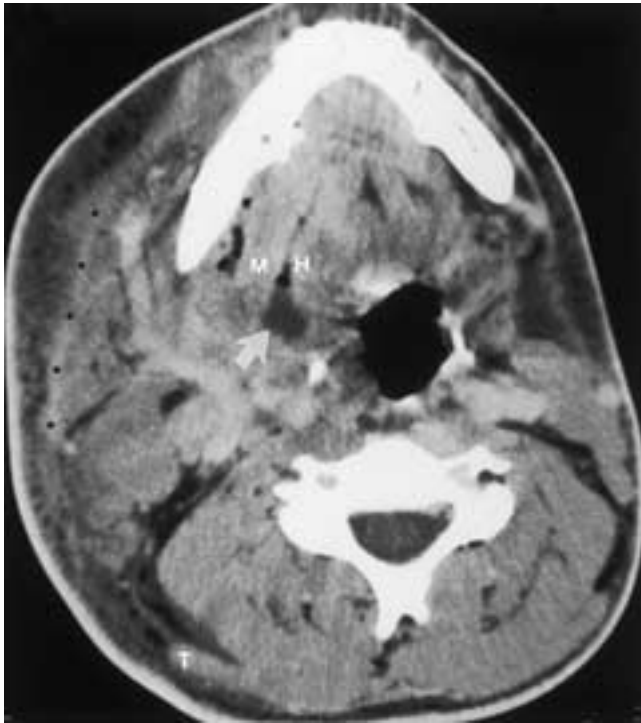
Abscess or cellulitis. Axial contrast-enhanced CT scan demonstrates a small abscess cavity (arrow) at the posterior aspect of the right tongue, between the mylohyoid (*M*) and hyoglossus (*H*) muscles, both of which are enlarged due to associated myositis. Small collections of gas can be seen to dissect between the muscle fibers. Marked cellulitis involving multiple fascial spaces is identified. The right platysma muscle (*black dots*) is markedly thickened, and the left muscle is much less affected. There is marked edema and a “dirty” appearance of the subcutaneous fat involving the right side of the face. The skin overlying this edematous fat is slightly thickened as well. This edema and cutaneous thickening extend posteriorly in the superficial space to at least the margin of the right trapezius muscle (*T*).
